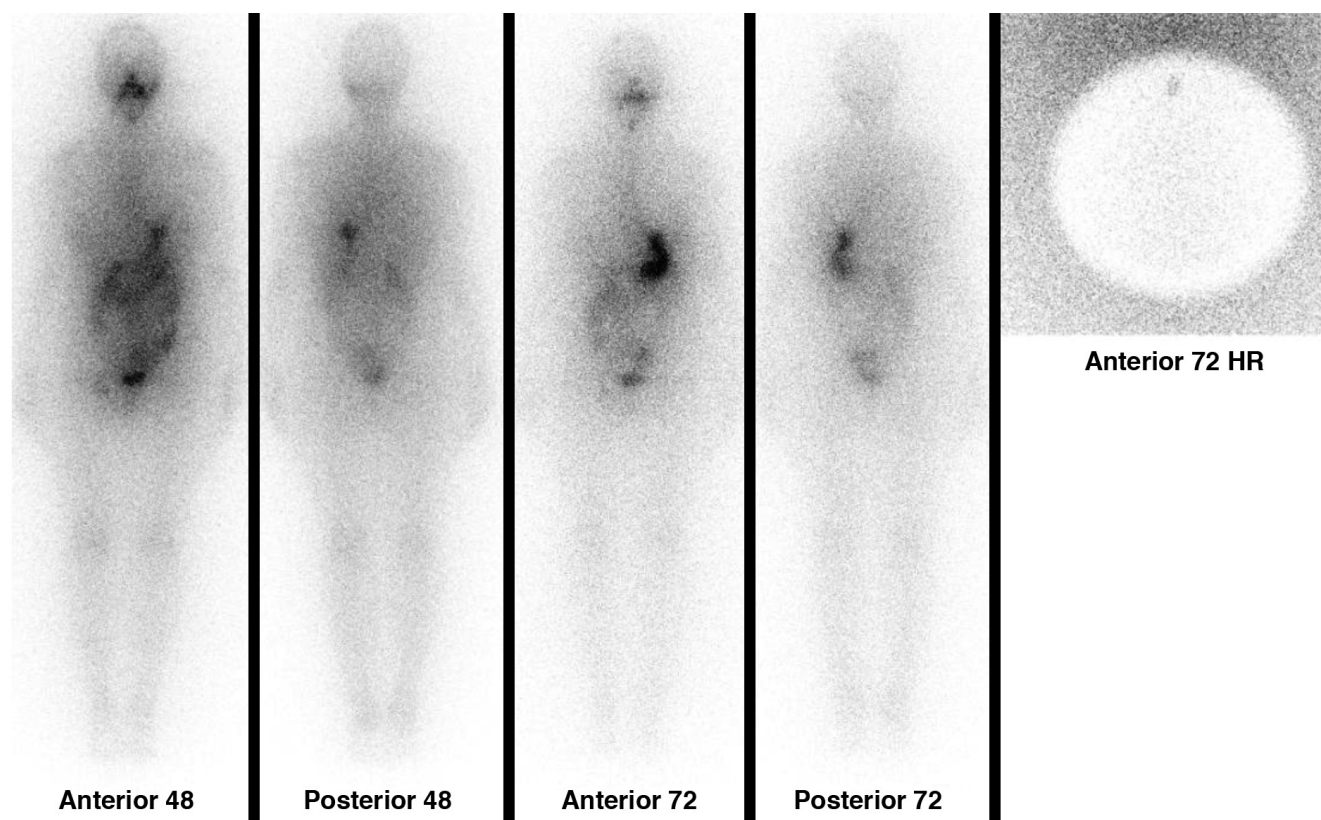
A 35-year-old woman with papillary thyroid carcinoma who had received 50 mCi iodine-131 (I-131) following total thyroidectomy underwent an I-131 whole body scan one year later. While serum levels of thyrotrophin-stimulating hormone was 92.22 mIU/L, thyroglobulin and anti-thyroglobulin antibody levels were 4.61 ng/mL and <0.9 IU/mL, respectively. I-131 whole body images were obtained by using a large field-of-view gamma camera (Siemens e.cam-signature; Siemens, Hoffmann Estates, Illinois, United States of America) in a 256x1024 matrix using a high energy parallel hole collimator and pinhole collimator at 48 and 72 hours. Images showed focal I-131 accumulation on the neck, located in the midline, along with I-131 uptake in the right inguinal region and the suprapubic area (Figure 1). The focal uptake on the neck was interpreted as residual thyroid tissue on the thyroglossal duct, and the suprapubic non-homogenous activity was attributed to uterine activity due to menstrual bleeding. The etiology of the right inguinal uptake was revealed with further evaluation. The patient was also suffering from groin pain during the menstrual period along with a right inguinal mass that enlarged at the same time. Right inguinal superficial ultrasound revealed a hypoechoic solid mass of 25x15 mm located in the neighborhood of femoral artery and multiple accompanying reactive lymph nodes with the largest dimensions measuring 43x8 mm. The Tru-Cut biopsy of the right inguinal palpable mass was performed that revealed endometriosis. Thyroglobulin elevation in our patient was associated with neck uptake and distant metastasis was excluded. Treatment was planned accordingly.
